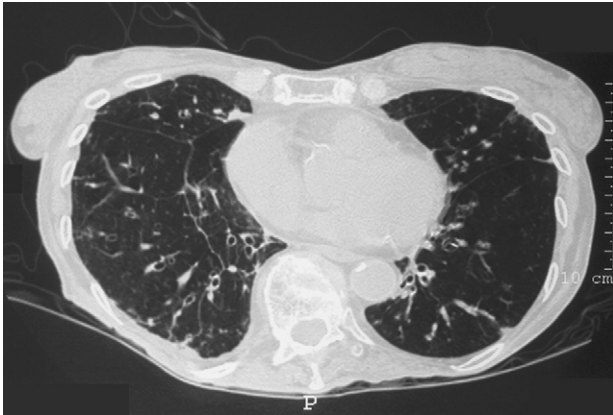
Elderly woman with diffuse bronchiectasis, predominantly in right lower lobe. The identification of *P aeruginosa* and, to a lesser degree, *H influenzae* in sputum should suggest the presence of bronchiectasis. Bronchiectasis is underdiagnosed in older patients. A clinical diagnosis is often difficult because auscultation, although suggestive, is non-specific, and crackles may be absent. When suspected, high resolution computed tomography should be used for definitive diagnosis.
